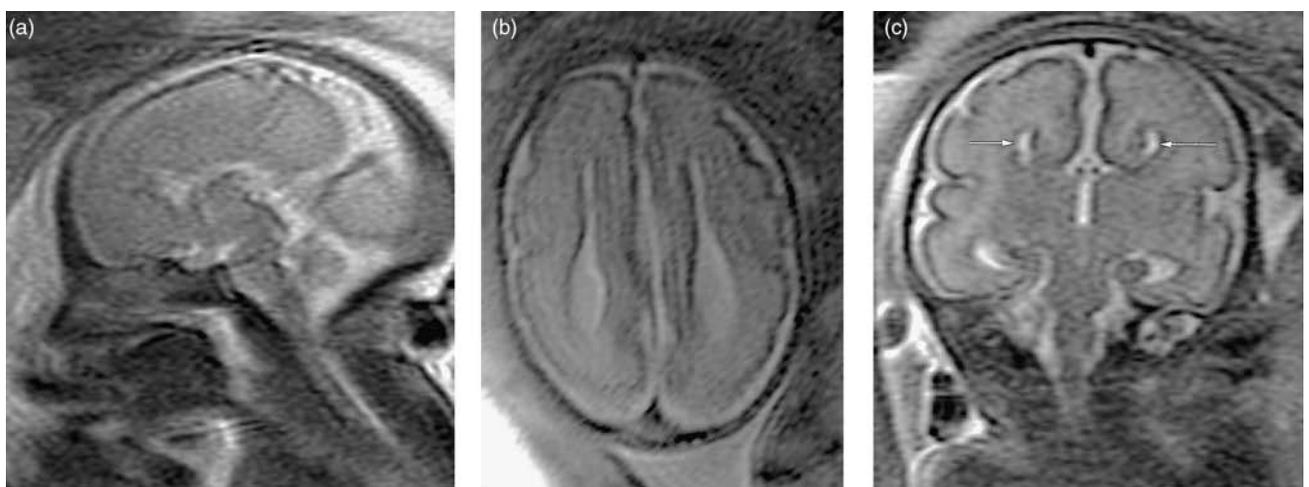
Agenesis of the corpus callosum at 20 weeks gestational age. Axial (a) and coronal (b) T<sub>2</sub>-weighted images demonstrate the parallel and vertical orientation of the frontal horns (white arrows) and lack of callosal tissue crossing the midline (black arrow). There is disproportionate prominence of the atria and occipital horns of the lateral ventricles (colpocephaly). The fetus also had an abnormal heart on prenatal sonography.
